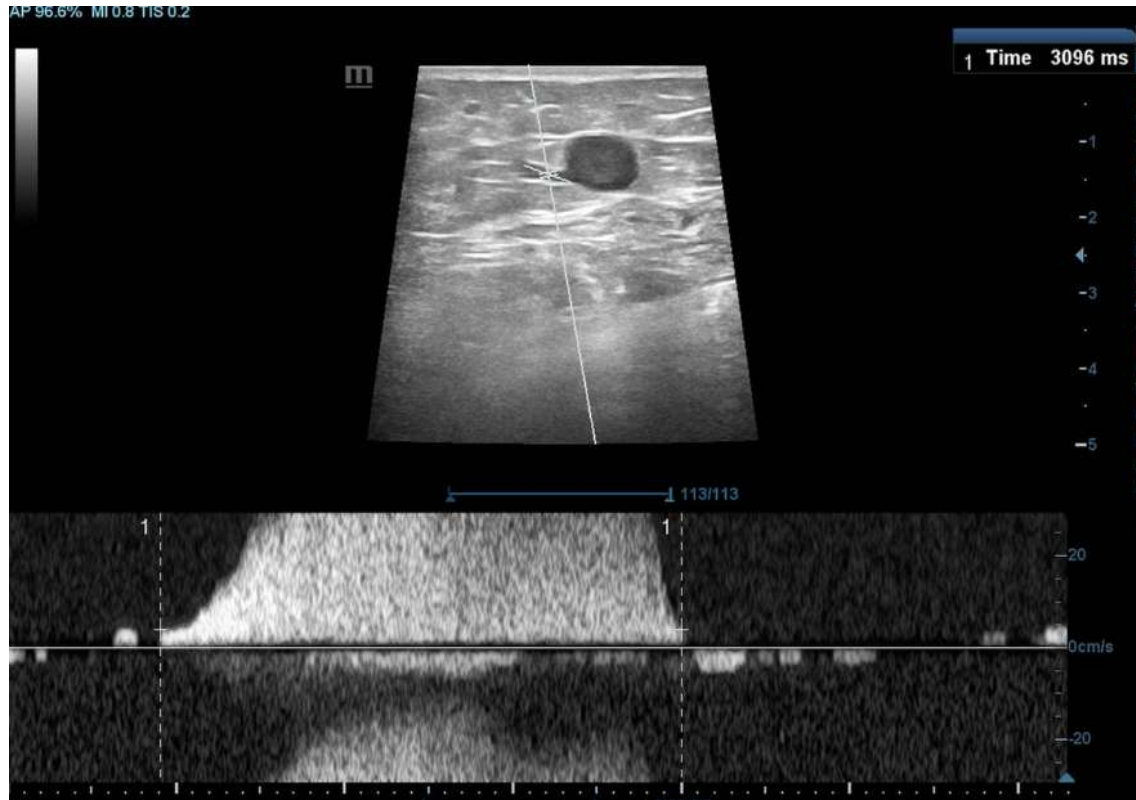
1 Spectral venous Doppler image of great saphenous vein with perforator at the level of mid thigh demonstrating prolonged retrograde venous flow (venous reflux) with a reflux duration of 3096 ms (3.096 s) which is suggestive of incompetent perforator of great saphenous vein.
